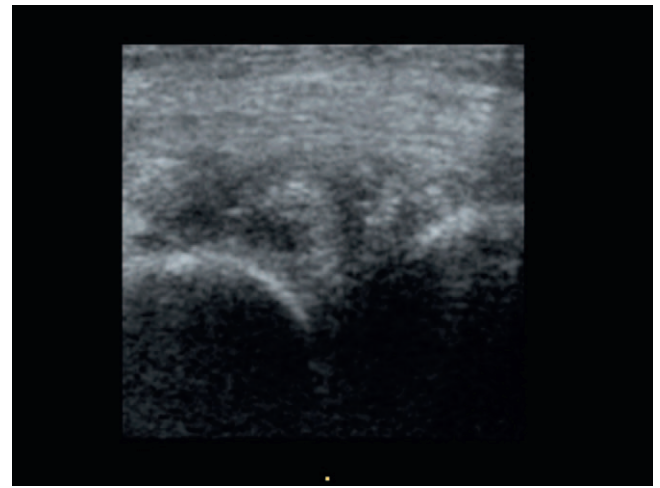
A bucket-handle tear of the medial meniscus demonstrated on two-dimensional ultrasonography.
